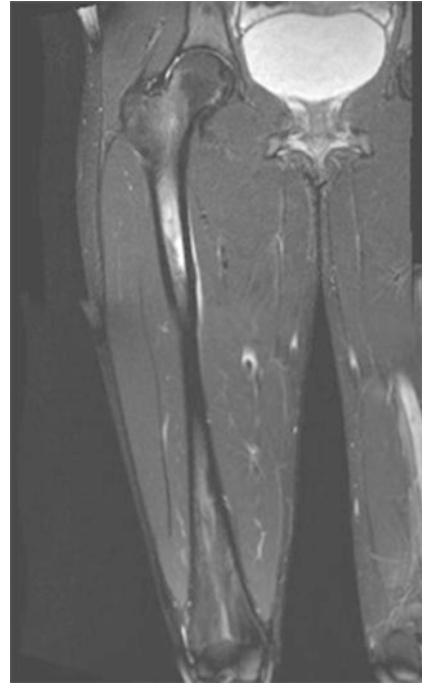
Coronal T2 MRI of the femur demonstrating the common location of femoral shaft stress fractures at the posteromedial junction of the proximal and middle third of the femur
